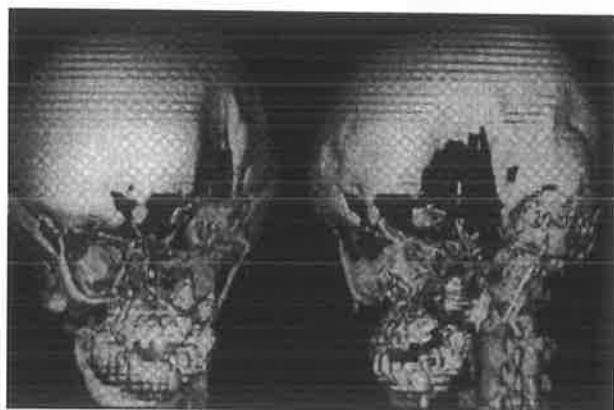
3D CT images displaying the extent of the osteolysis.*
